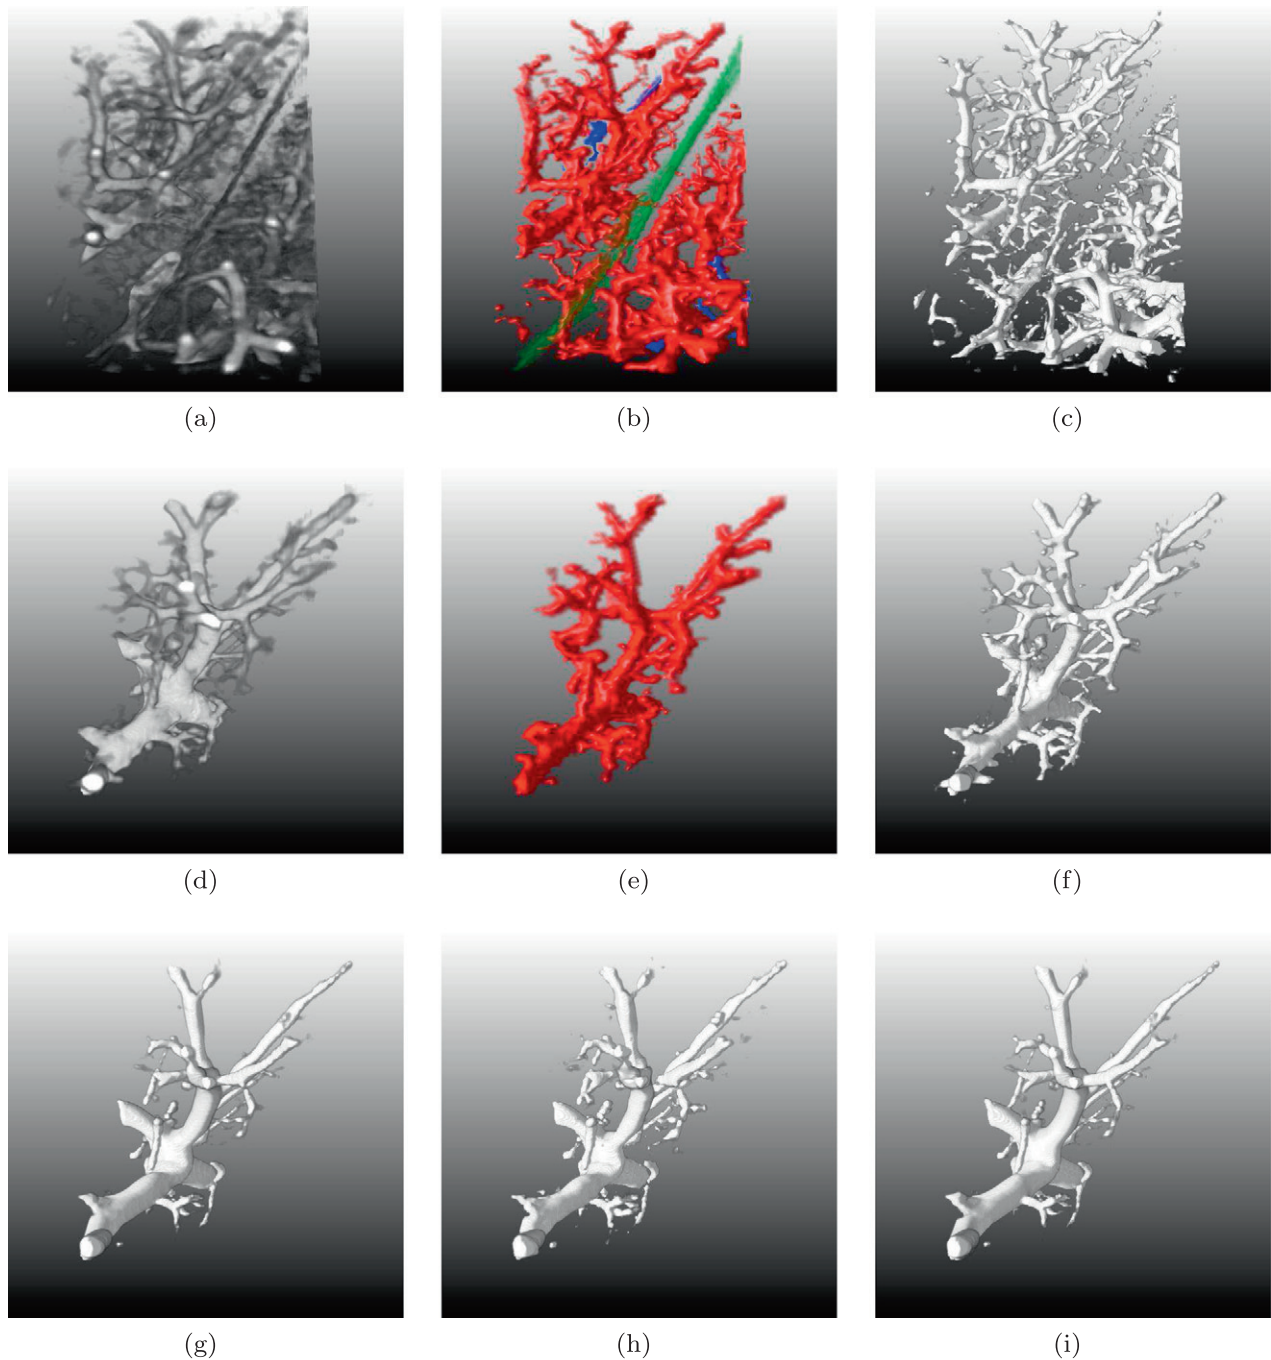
The first non-contrast-enhanced pulmonary CT dataset experiment. (a) original image; (b) manually segmented reference standard; (c) filtered image of our method; (d)–(i) are the extracted ROI from the original image, reference standard, the filtered results of proposed, Frangi, Li and Sato method, respectively.
